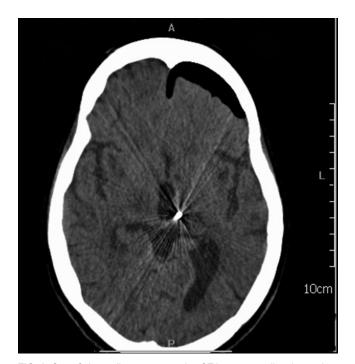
Case 6. Immediate postoperative CT image revealing the position of the electrode and the presence of intracranial air with no visible sign of hemorrhage.
